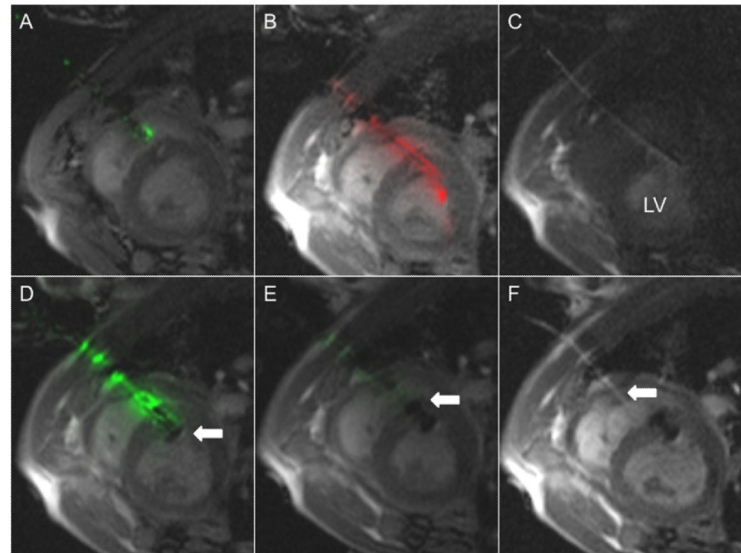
Real-Time MRI Guidance of Muscular VSD Occluder Delivery
